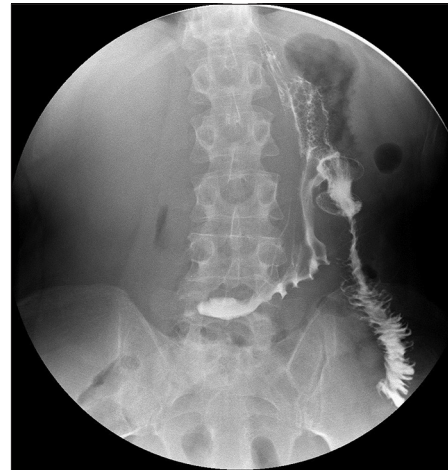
24-h contrast X-ray after EUS-gastroenterostomy: Lumen apposing metal stent correct positioning and patency
